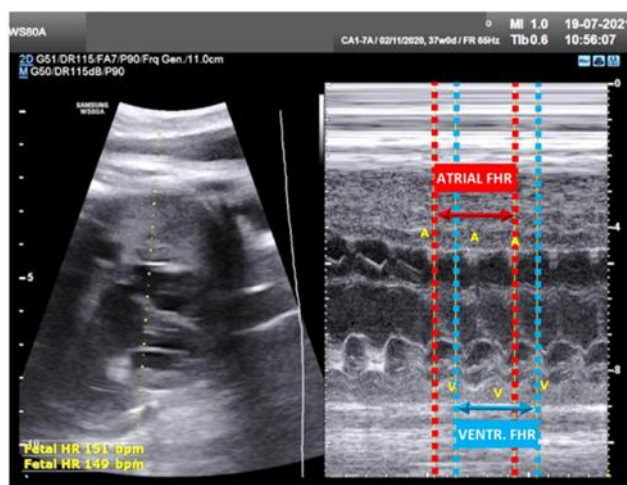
Results of the M-mode echocardiogram (Date: July 19th, 2021). It showed the resolution of tachyarrhythmias, a regular atrial heart rate of 151 bpm, and a ventricular heart rate of 149 bpm
